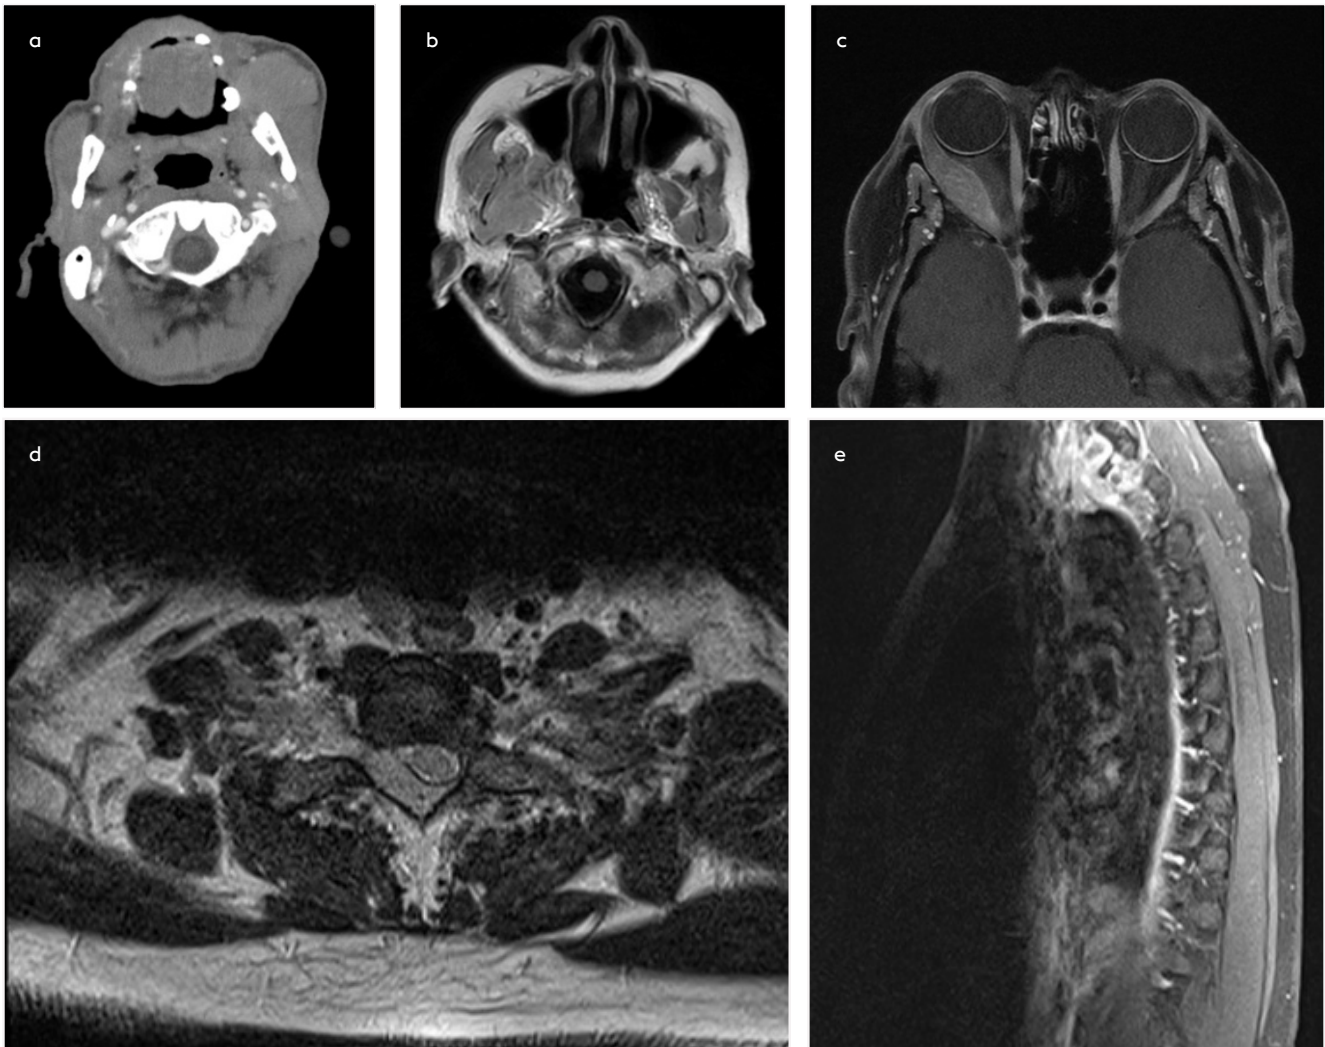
a-e. Muscles and plexus involvements by Non-Hodgkin lymphomas Axial contrast-enhanced CT image demonstrate secondary involvement of left side masseter muscle (a). Secondary involvement of the right side masticator space with pterygoideus muscles (b) and secondary involvement of right side lateral rectus muscle (c) are shown on axial contrast-enhanced T1WIs. Axial (d) and sagittal (e) contrast-enhanced T1 weighted images show secondary involvement of right brachial plexus.
